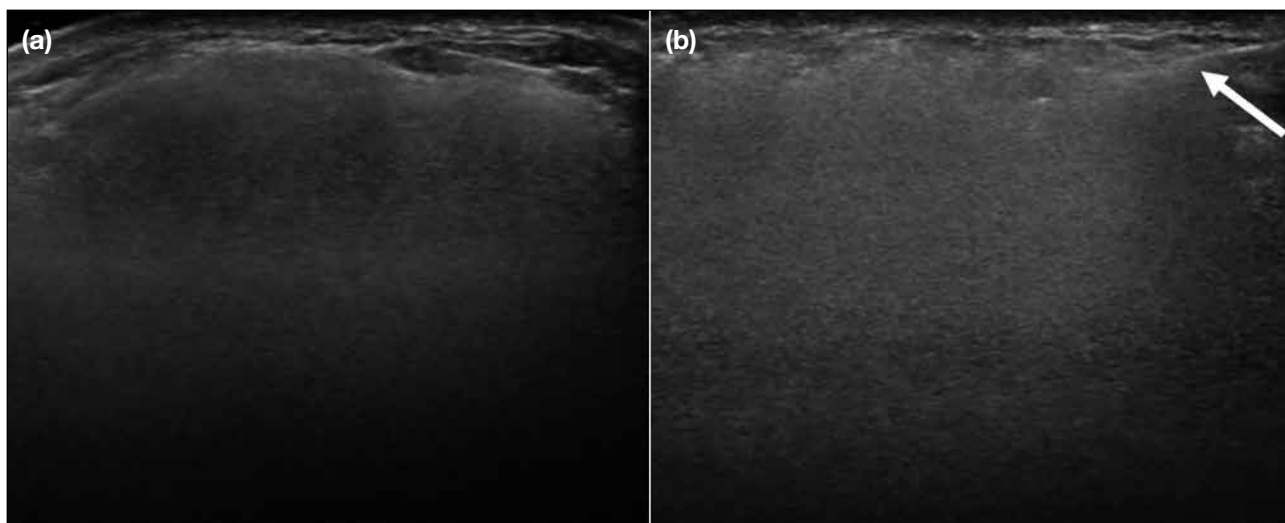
(a) Ultrasound at left 5 o'clock (L5H) position with snowstorm appearance caused by free silicone injection. (b) Ultrasound-guided biopsy at L5H position with limited visualisation of the biopsy needle (arrow).
